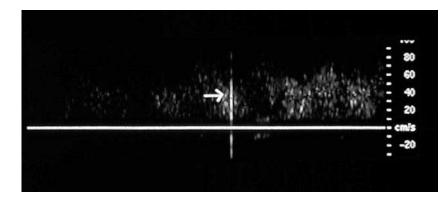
Spectral Doppler display from a dialysis fistula showing a high-intensity signal of very brief duration (MES) during hemodialysis.
